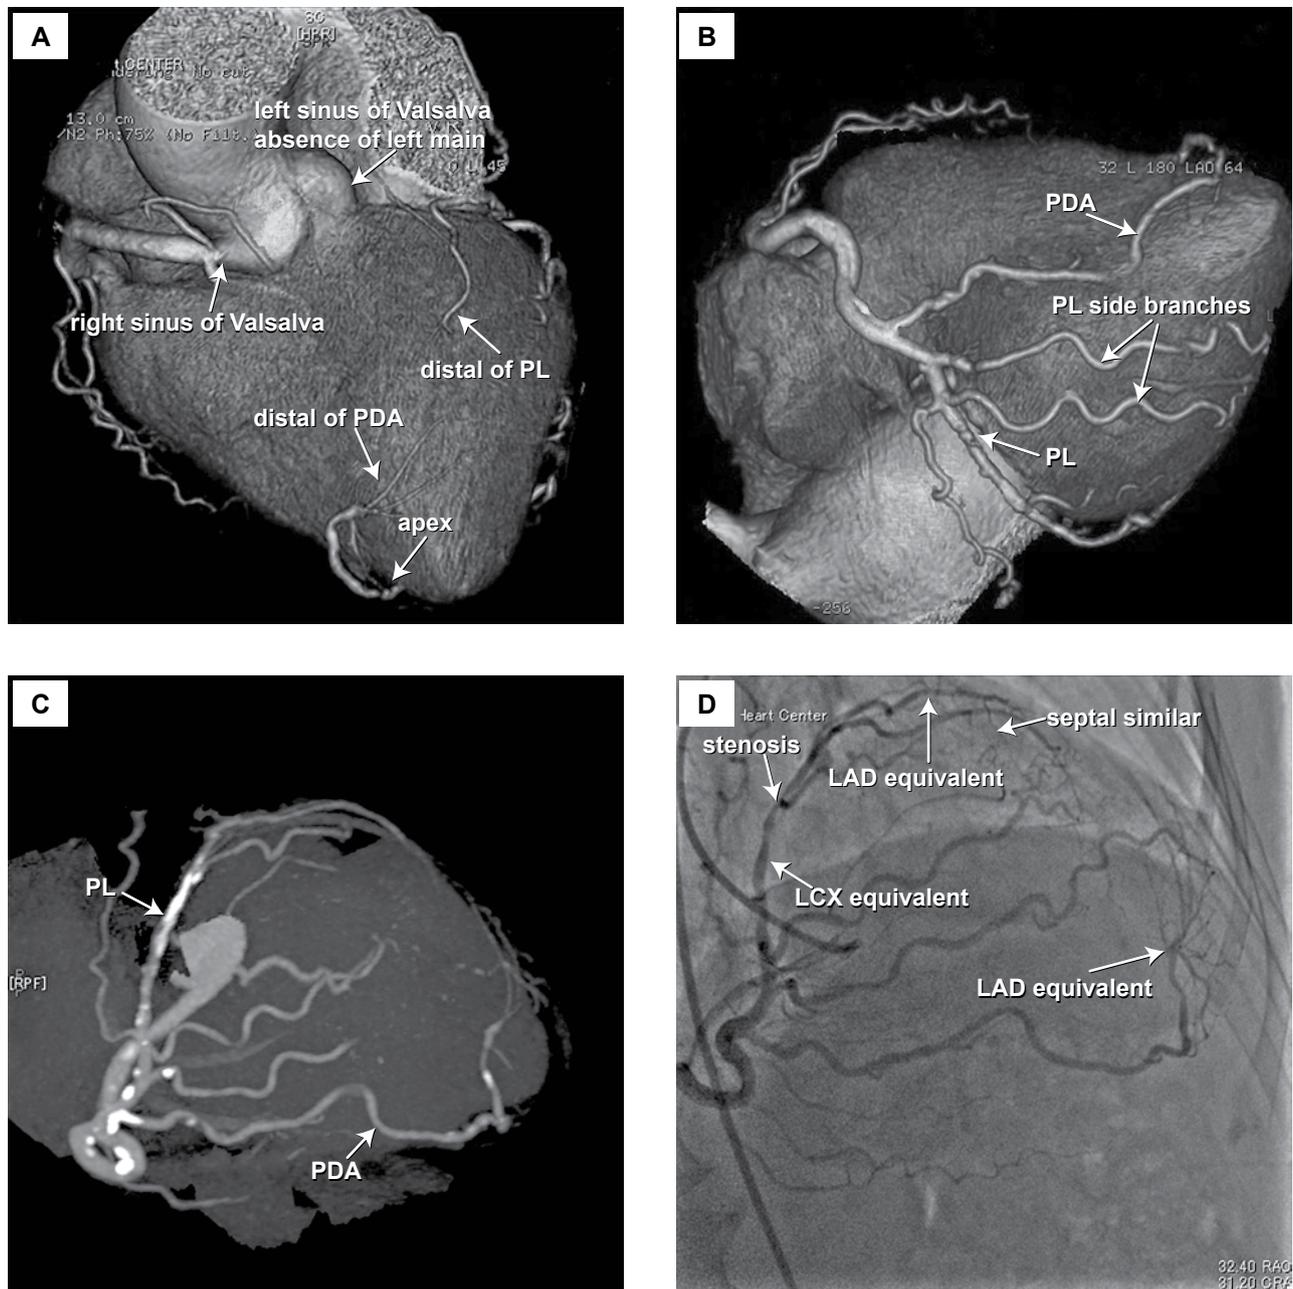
Multislice cardiac computed tomography and angiography images show the isolated single right coronary artery and the total course of the right coronary artery; a moderate stenosis is identified in the middle posterolateral branch. LAD – left anterior descending; LCX – left circumflex; PDA – posterior descending artery; PL – posterolateral branch.
